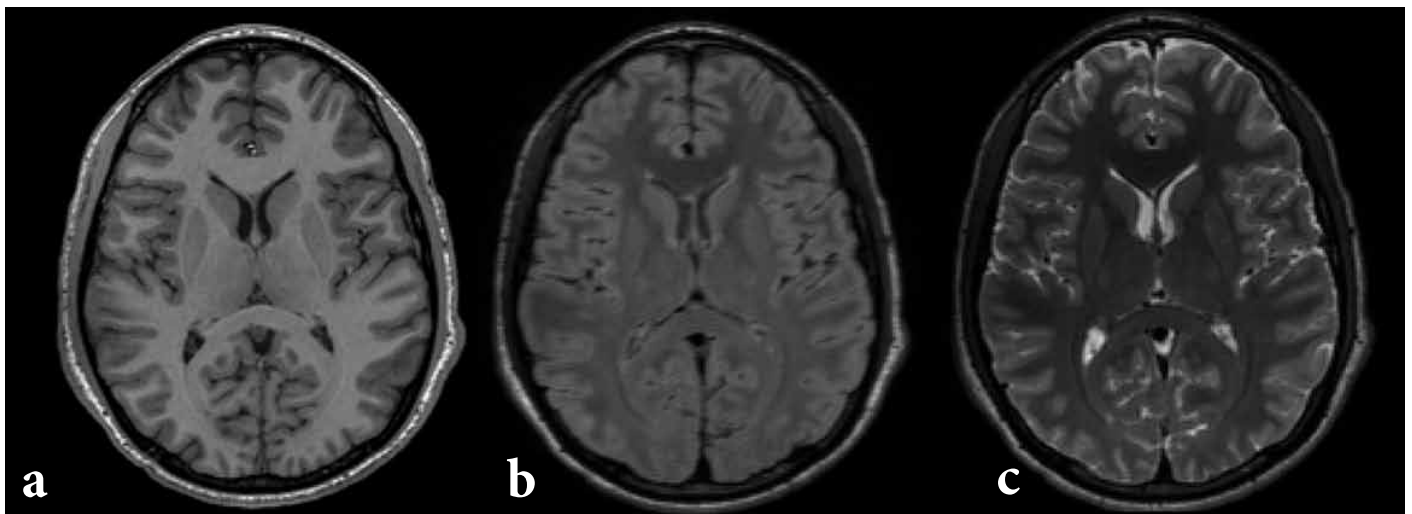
Axial brain MRI image of the same tissue showing how image weighting can be used to vary the contrast between grey matter, white matter and cerebrospinal fluid. (a) T1 weighted, (b) proton density weighted, and (c) T2 weighted MRI sequences.
